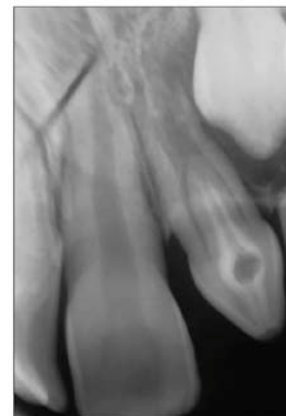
Periapical radiograph of tooth #10 with dens invaginatus Type II.
